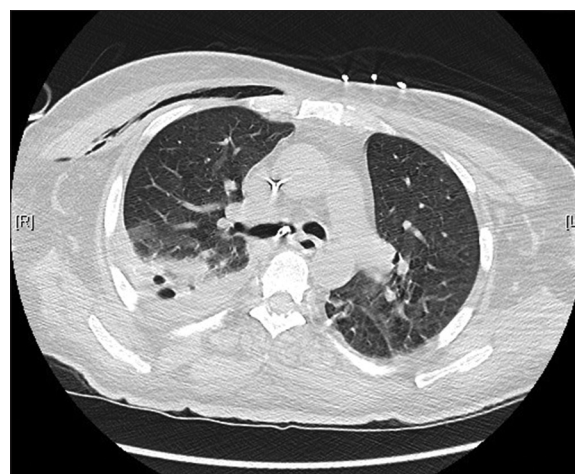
This computed tomography image performed after insertion of a chest drain reveals the nasogastric tube within the right main bronchus. It also demonstrates right lower zone consolidation and a pleural effusion
